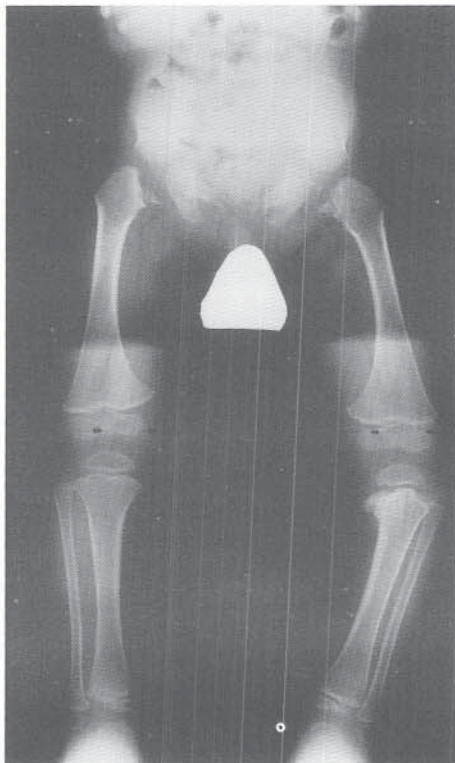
Radiographic abnormalities in SED congenita include delay in ossification of the femoral heads and coxa vara.
